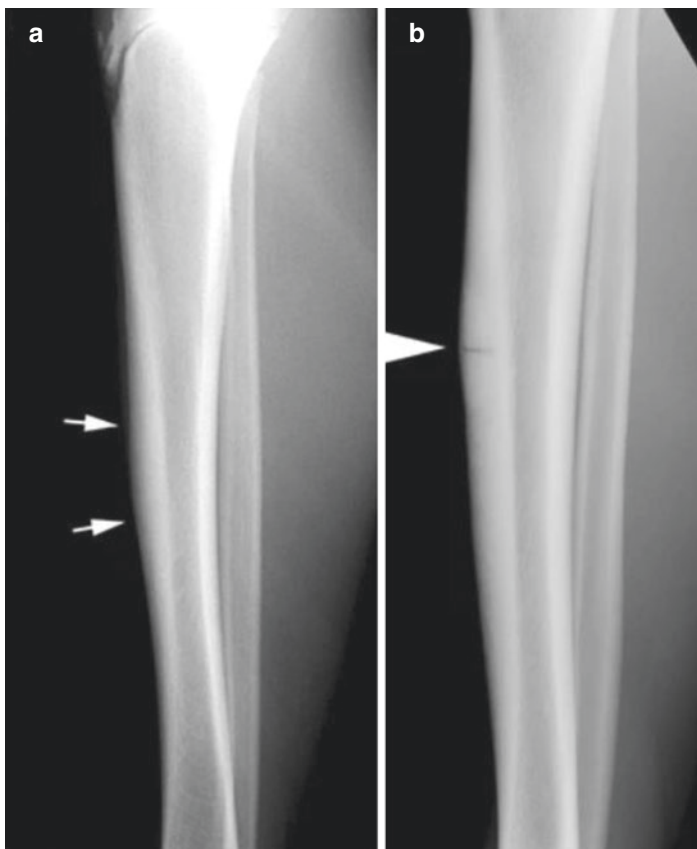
Plain films: bony changes. (a) In this patient, only focal thickening of the anterior cortex (arrows) is seen. (b) In this patient, in addition to such thickening, an actual transverse stress fracture. (Used with permission from: Swischuk and Jadhav [36])
